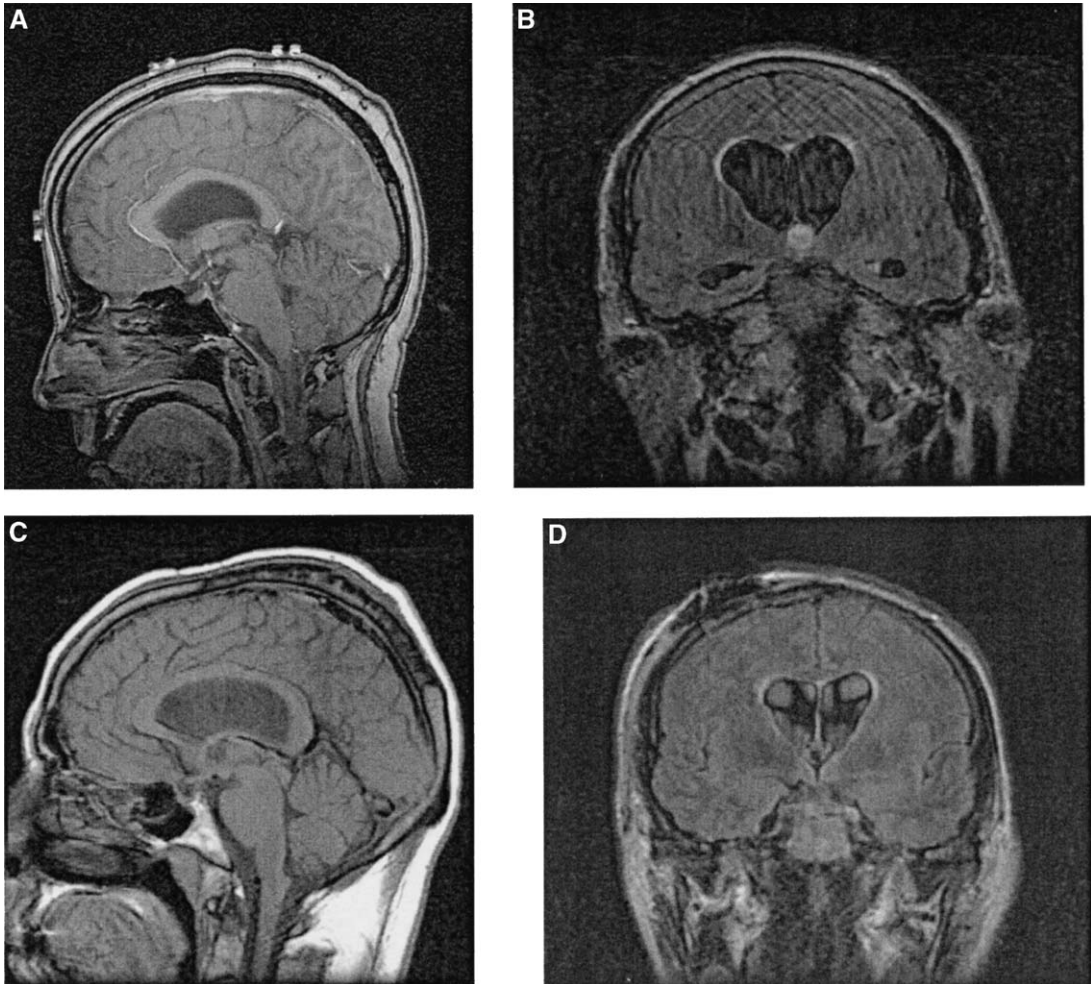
(A, B) Preoperative sagittal precontrast T1-weighted and coronal fluid attenuated inversion recovery (FLAIR) images demonstrating the colloid cyst associated with hydrocephalus. (C, D) Postoperative imaging after endoscopic cyst resection. No visible remnant of the cyst is seen, and the ventricles have decreased in size. The patient's imaging studies show no cyst recurrence at 24 months of follow-up.
